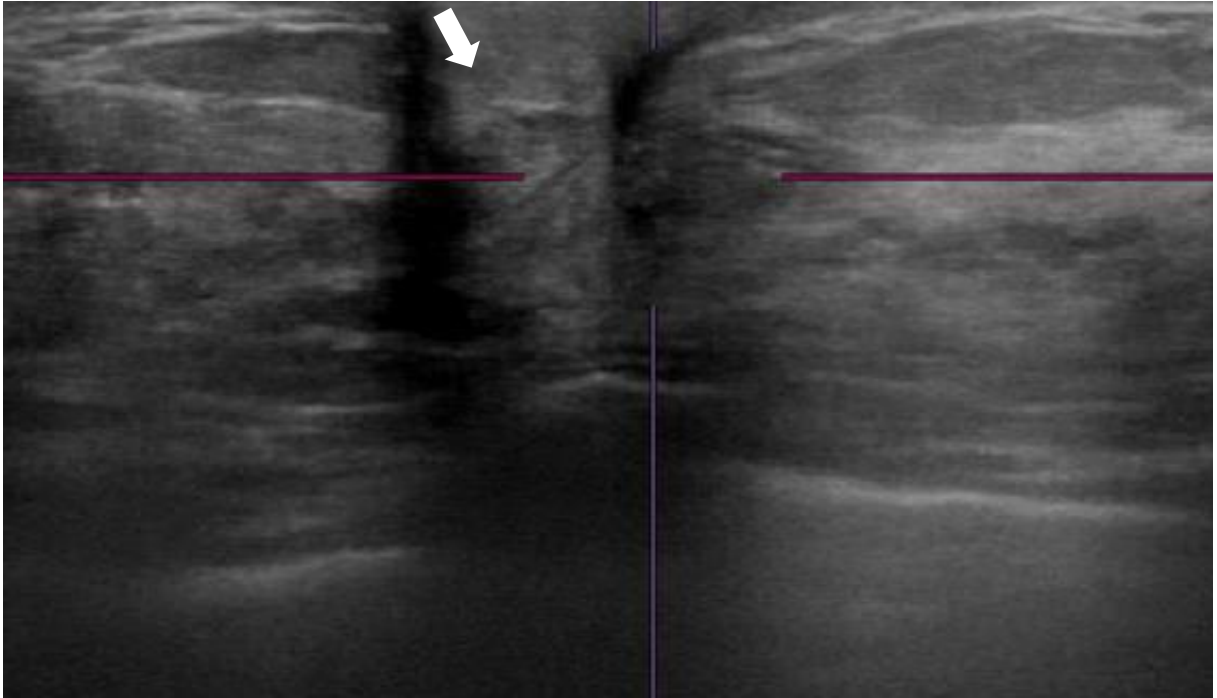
Ultrasound of the breast showing disruption of Cooper ligament (white arrow)
